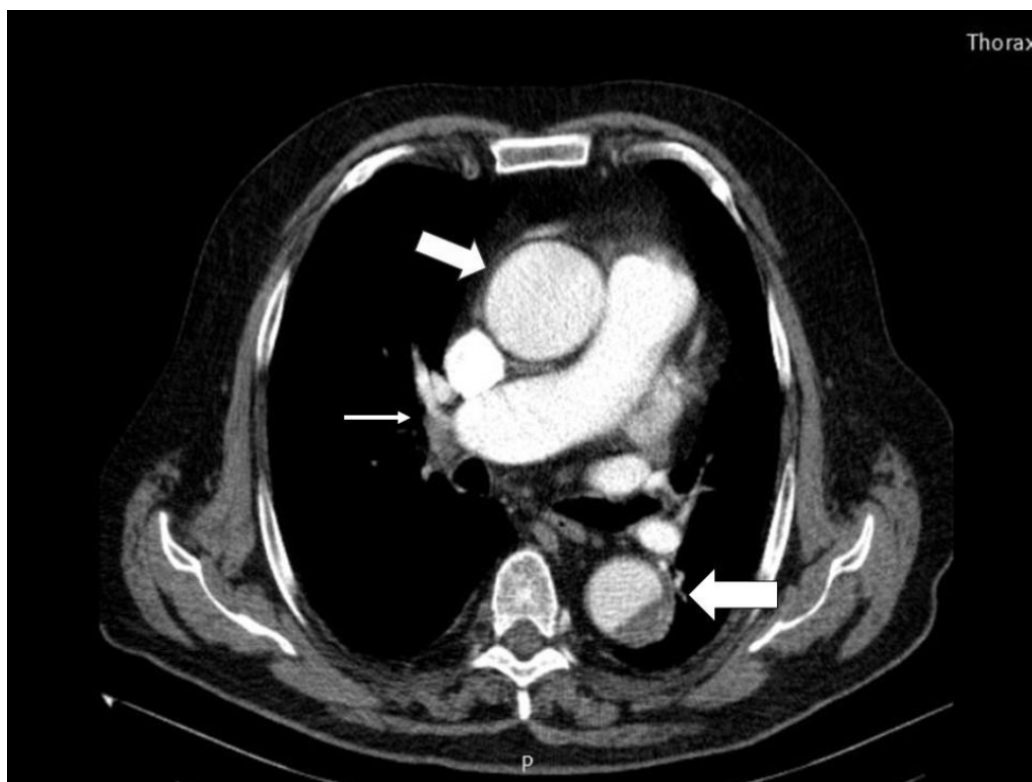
Thoracic angio CT: Right segmentary pulmonary embolism (white arrow), respectively dilated ascending aorta and descending aortic dissection (white lines).
